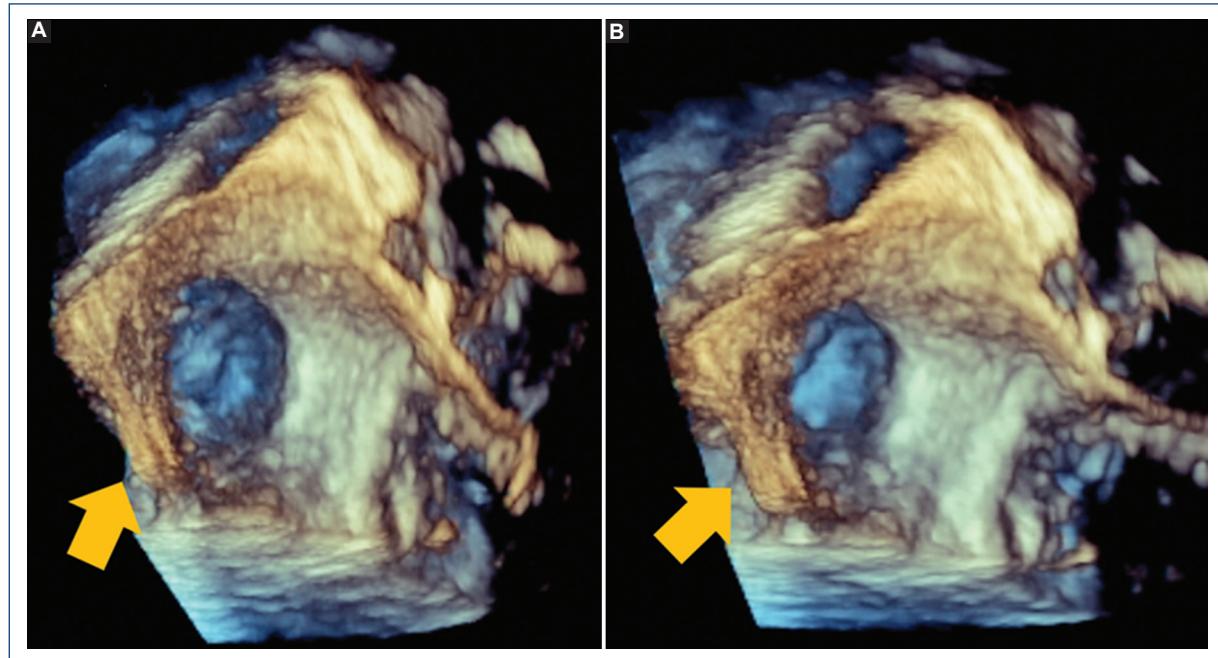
A and B: transesophageal echocardiogram: 3D view from the left atrial appendage showing coumadin ridge (yellow arrow).
